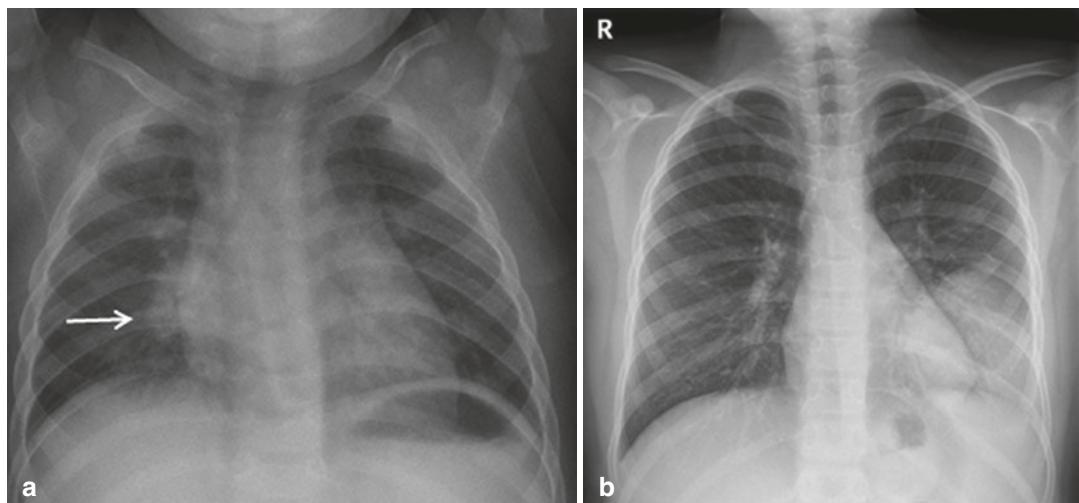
Frontal chest radiograph of (a) a 2-year-old boy with an ill-defined right perihilar round pneumonia (arrow), (b) a 7-year-old girl showing a well-defined round pneumonia in the left lower lobe (LLL), and (c) an
